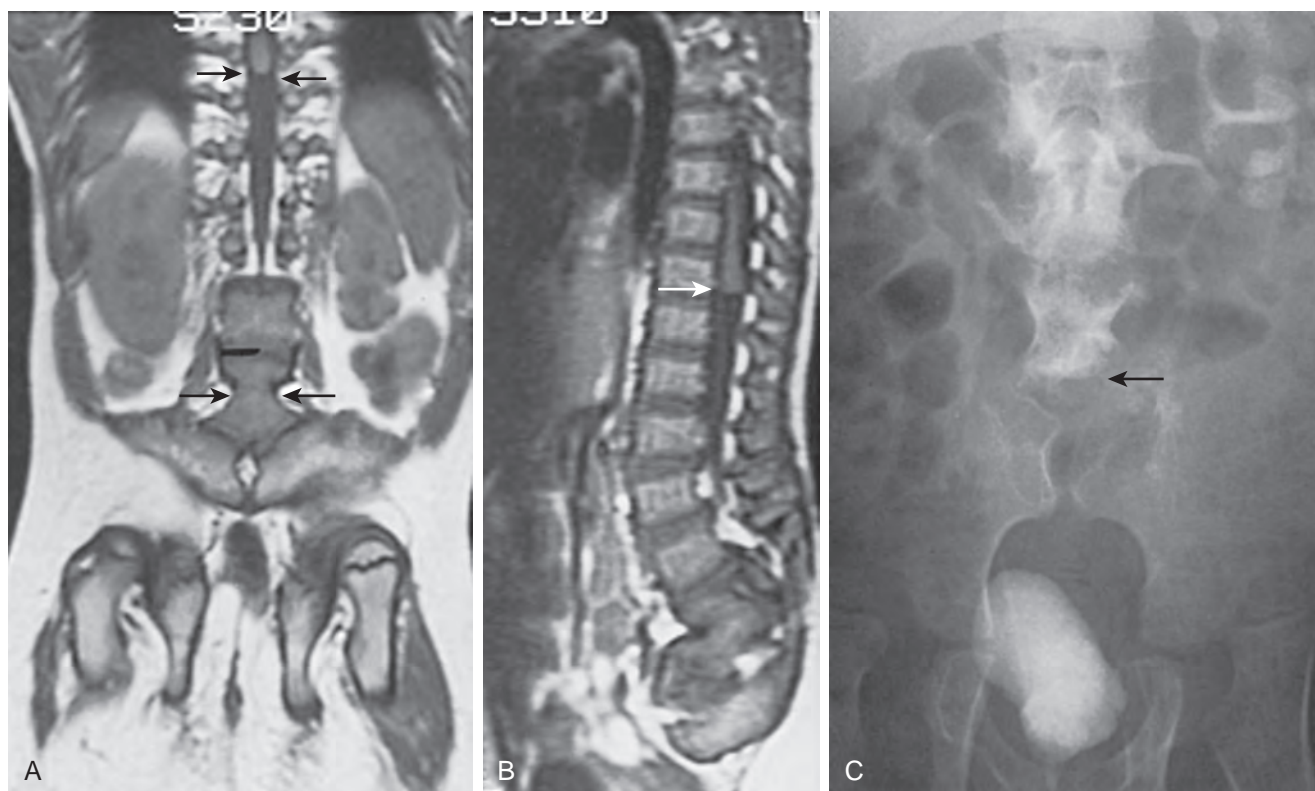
Coronal (A) and sagittal (B) magnetic resonance images in a 10-year-old boy with sacral agenesis beginning at L5. Note the squared lower limit of the cord adjacent to T11 (A, upper arrows; B, white arrow) and the two sacroiliac joints (A, lower arrows), which are in the midline because of absence of the sacrum. C, An anteroposterior radiograph from an excretory urogram shows no vertebral bodies below L4 (arrow).
